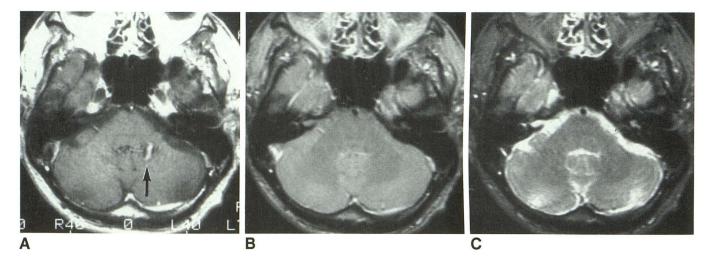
A-C, Postcontrast T1-weighted image (A) shows area of increased signal (arrow) adjacent to fourth ventricle, representing flow-related artifact. Postcontrast spin-density-weighted (B) and T2-weighted (C) images show that this area is normal and confirm that the finding is an artifact.
